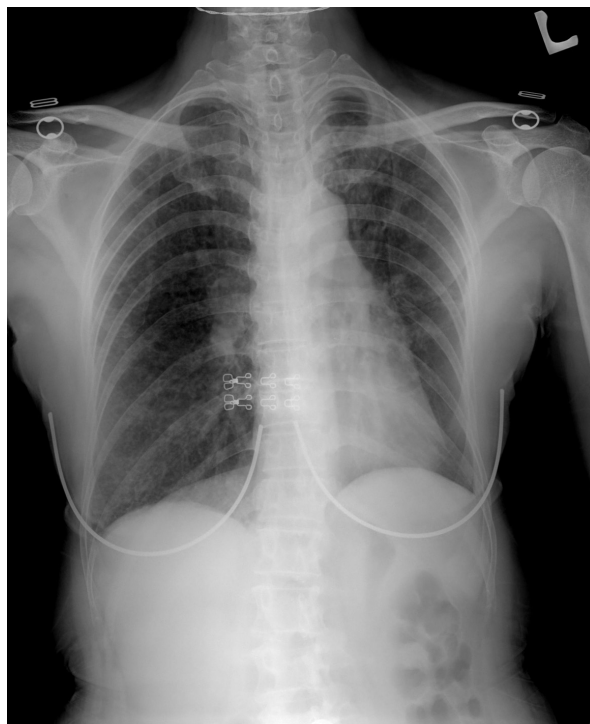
Chest X-ray revealing diffuse micronodular infiltrative shadows and tram lines in both lung fields.
